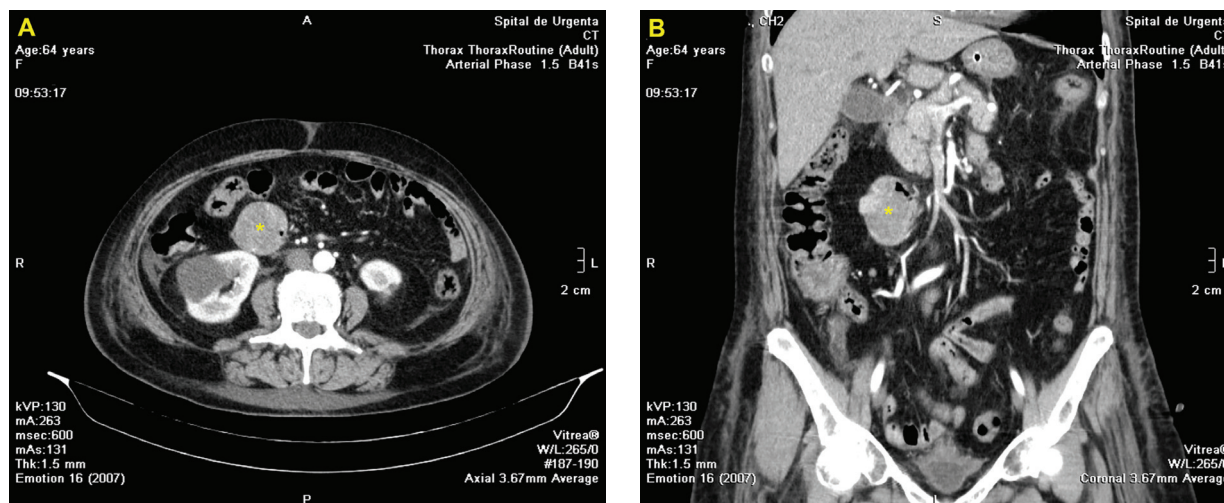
Computed tomography (CT) with angiography (A) axial and (B) coronal projections: a 4.6x4.4x6.1 cm solid mass in the proximal jejunum (*)
